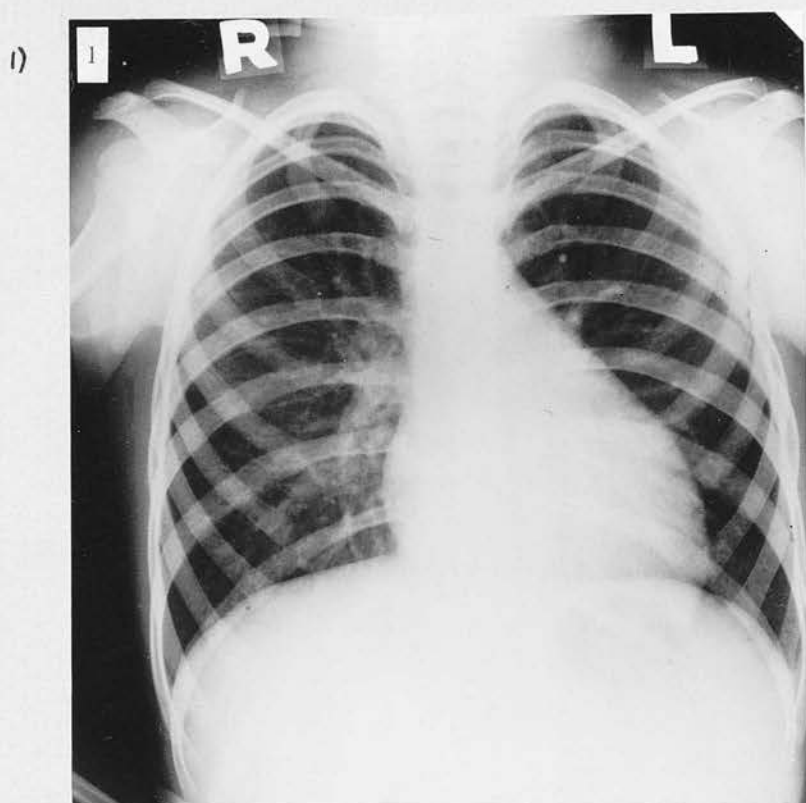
Radiograph of Case 22. Little change in cardiac size throughout school life.
